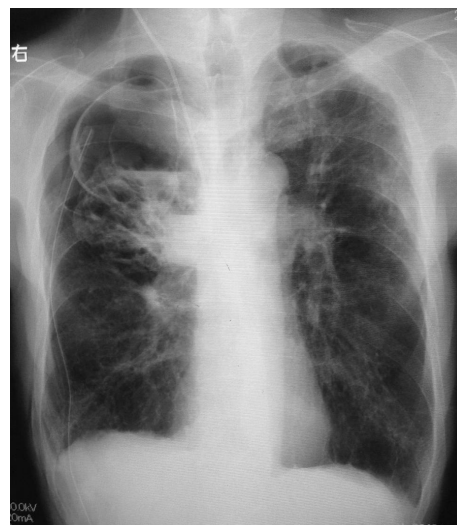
Chest radiography after chest drainage shows a bulla and intra-bulla fluid in the right upper lung field.
